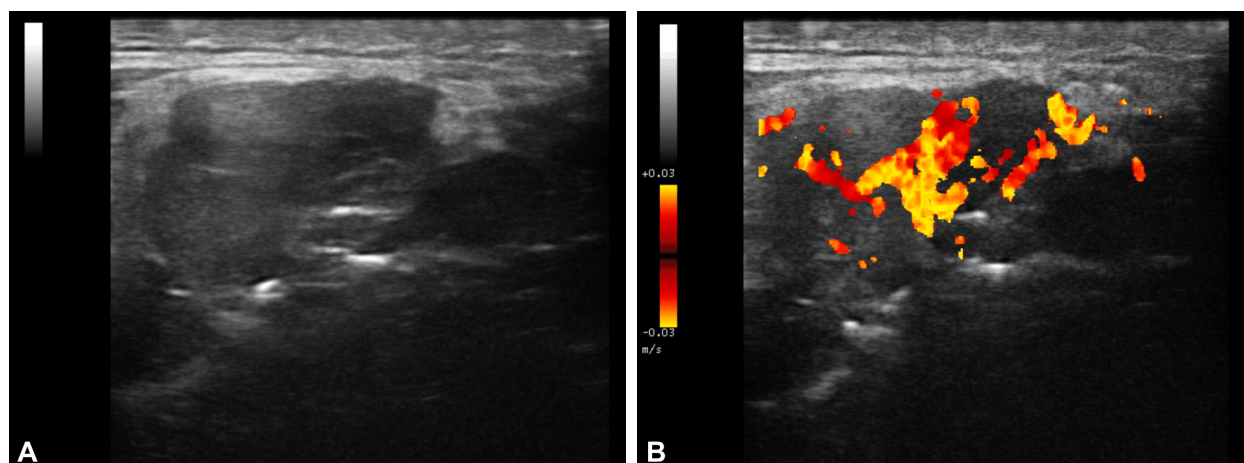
Grayscale (A) and Doppler (B) ultrasound examination of the left gluteal mass.
